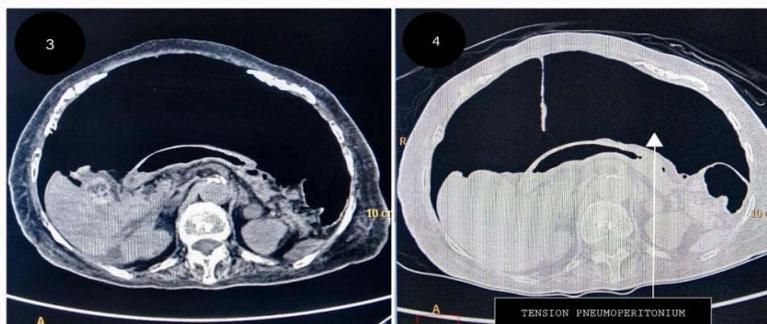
HRCT chest showing tension pneumoperitonium probably secondary to bowel perforation.
